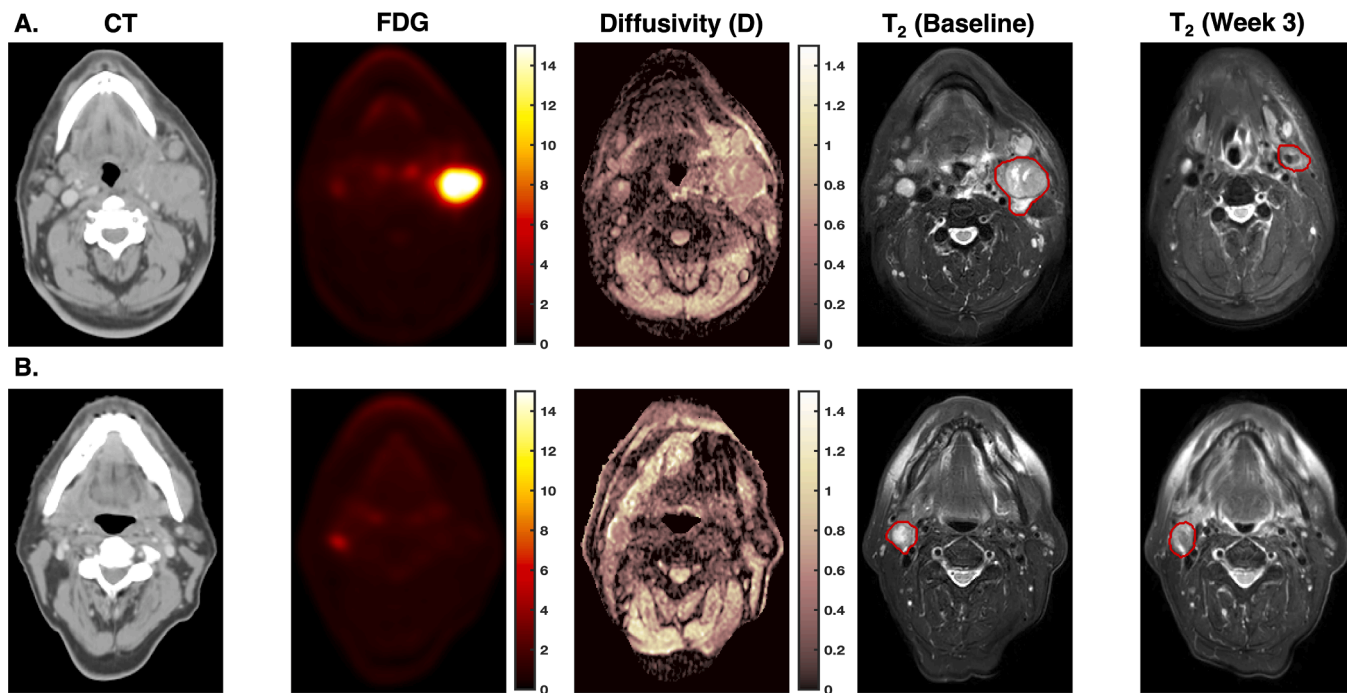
Example pre-treatment and week-3 imaging for two patients in this study. The patient in panel A (male, age 56 years) showed high baseline FDG uptake ($SUV_{mean} = 8.3$) and exhibited $>75\%$ volume loss upon week-3 imaging. In contrast, the patient in panel B (Male, age 67 years) showed pre-treatment $SUV_{mean} = 2.15$ and only 0.8% volume loss at week-3 of treatment.
